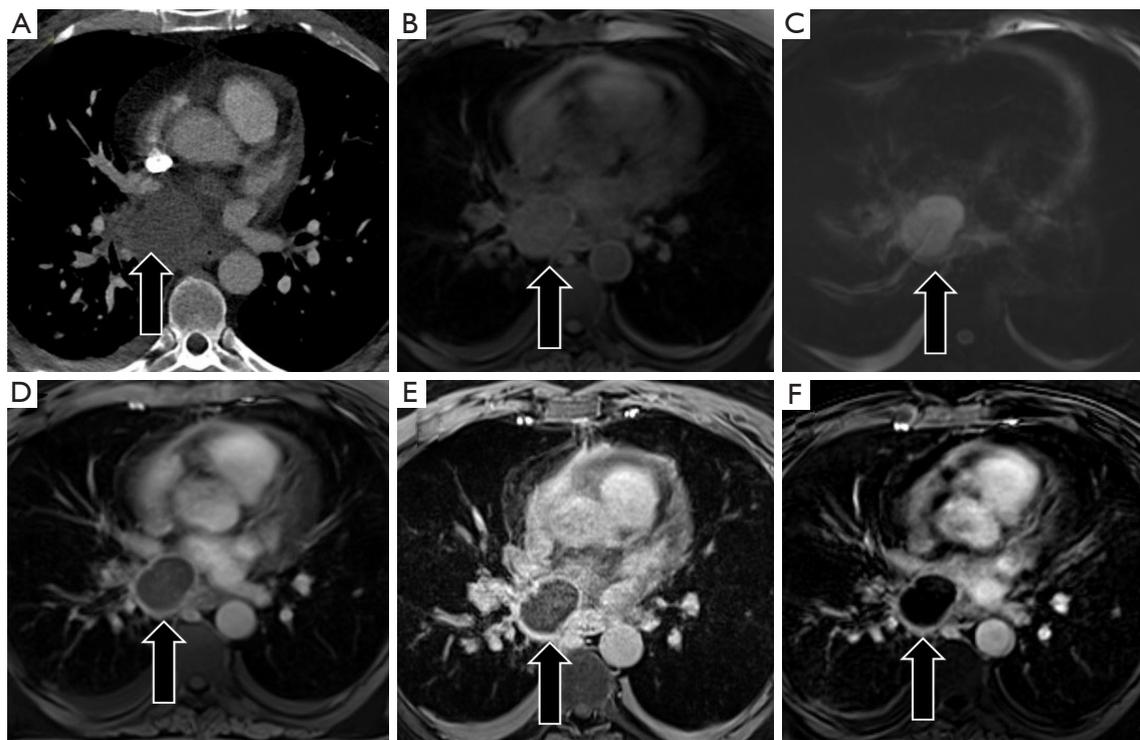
In this 47-year-old male, an esophageal duplication cyst underwent biopsy and subsequently developed an infection. Contrast-enhanced CT demonstrates a non-enhancing, intermediate density lesion in the visceral compartment (A, black arrow). MRI demonstrates intermediate to high T1 (B, black arrow) and high T2 signal (C, black arrow) within the lesion. After the intravenous administration of gadolinium, there is a peripheral capsular enhancement without internal septations or solid enhancing component (D and delayed acquisition E, black arrow). This is confirmed on subtraction images (F, black arrow). CT, computed tomography; MRI, magnetic resonance imaging.
